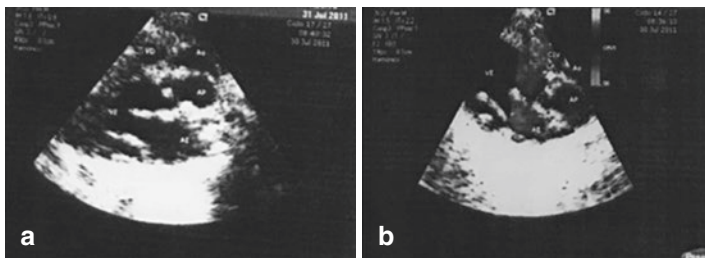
(a) Transthoracic echocardiography showing TGA. (b) Transthoracic echocardiography showing TGA with VSD
